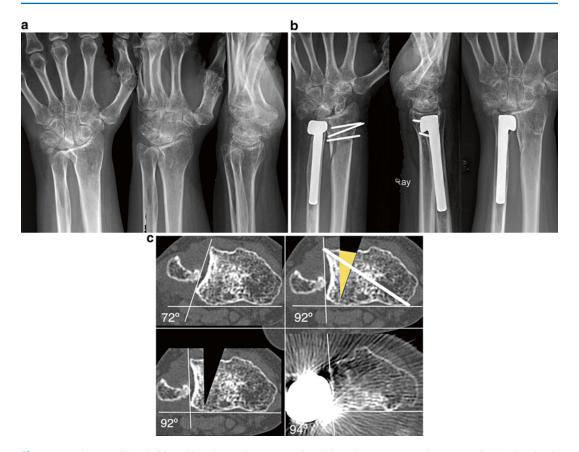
Rheumatoid arthritis with advanced DRUJ destruction, managed with sigmoid notch osteoplasty. (a) At time of surgery, the dorsal aspect of the sigmoid notch was clearly eroded and would not contain the native head or a trial ulnar component. A dorsal sigmoid notch osteoplasty was performed with the aim of stabilizing the component. (b) The ulnar head arthroplasty is well contained due to the sigmoid notch osteoplasty. Note that on the lateral view the ulnar head is now reduced. (c) Sigmoid notch osteoplasty. (i) Preoperative CT scan with abnormal shaped sigmoid notch. (ii) The aim was to perform a 200
